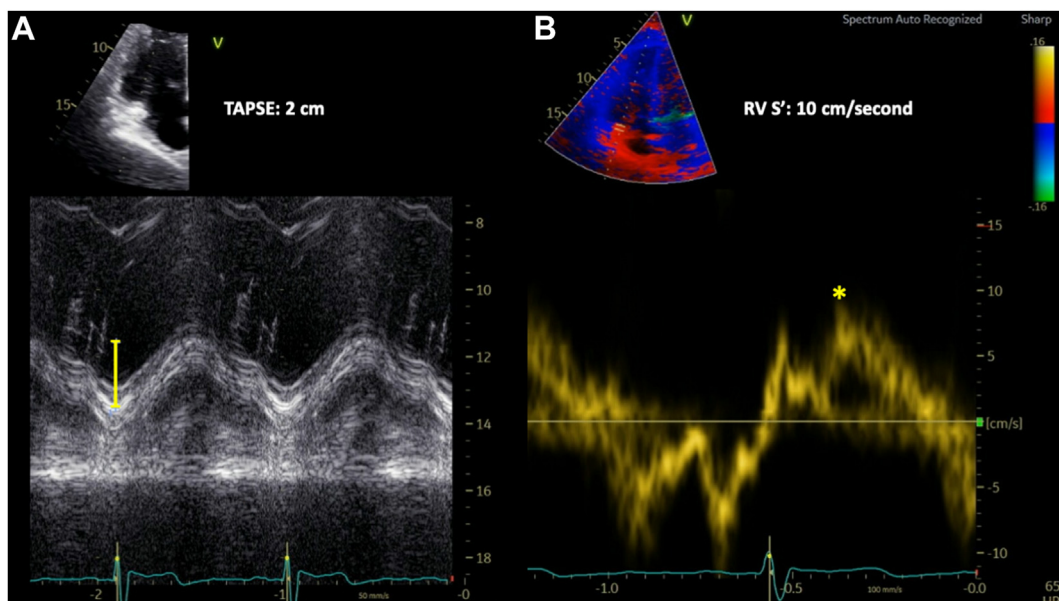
Two-dimensional TTE, RV-focused view with (A) M-mode assessment of tricuspid annular planar systolic excursion (TAPSE) and (B) tissue Doppler S', demonstrates preserved RV longitudinal systolic function.
